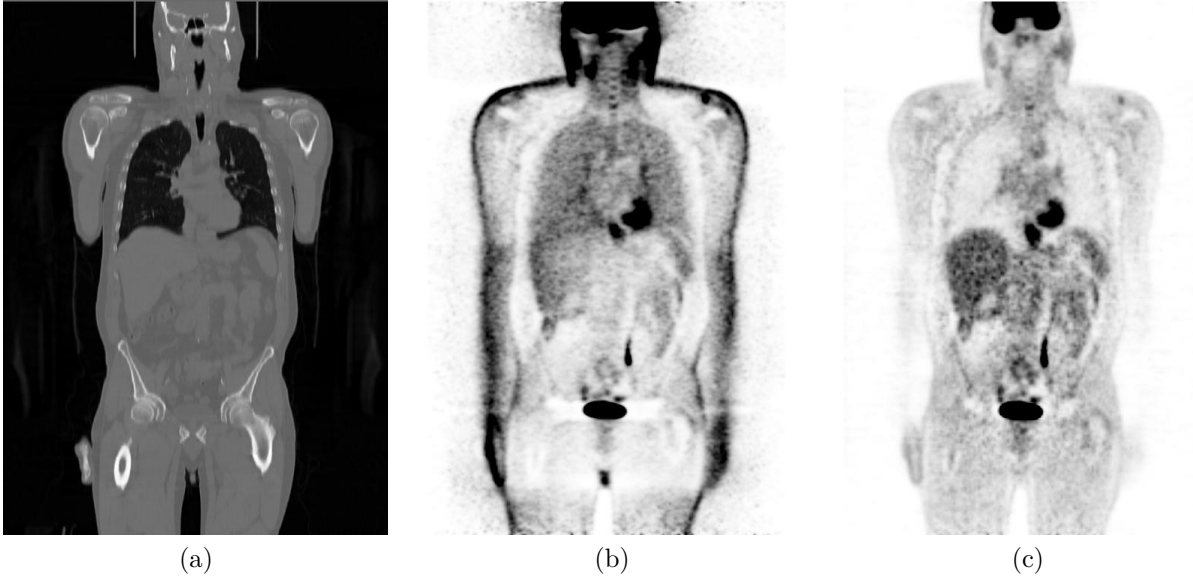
Corresponding coronal slices from a combined PET/CT machine: (a) CT, (b) PET without attenuation correction (c) PET after CT-based attenuation correction. Dark regions in the PET data correspond to high metabolic activity. Note the typical enhanced activity in the region of the lungs prior to attenuation correction.
